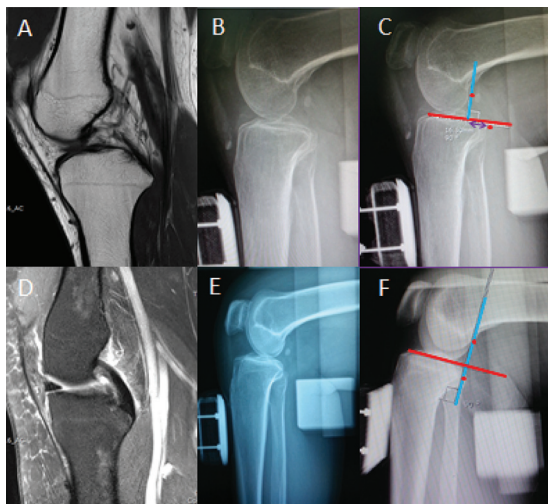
The MRI images show complete rupture of PCL (A) and healthy PCL (D). The posterior stress radiography in the 90 degrees knee flexion position with SRD shows posterior tibia translation of 16.50 mm distance (B, C) while no posterior tibia translation is seen in healthy PCL (E, F). The measurement of the distance of the most posterior contour of the medial femoral condyle and medial tibia plateau projected perpendicular to the medial tibia articular line (medial-medial method, MM method) in the 90 degrees of knee flexion position.
